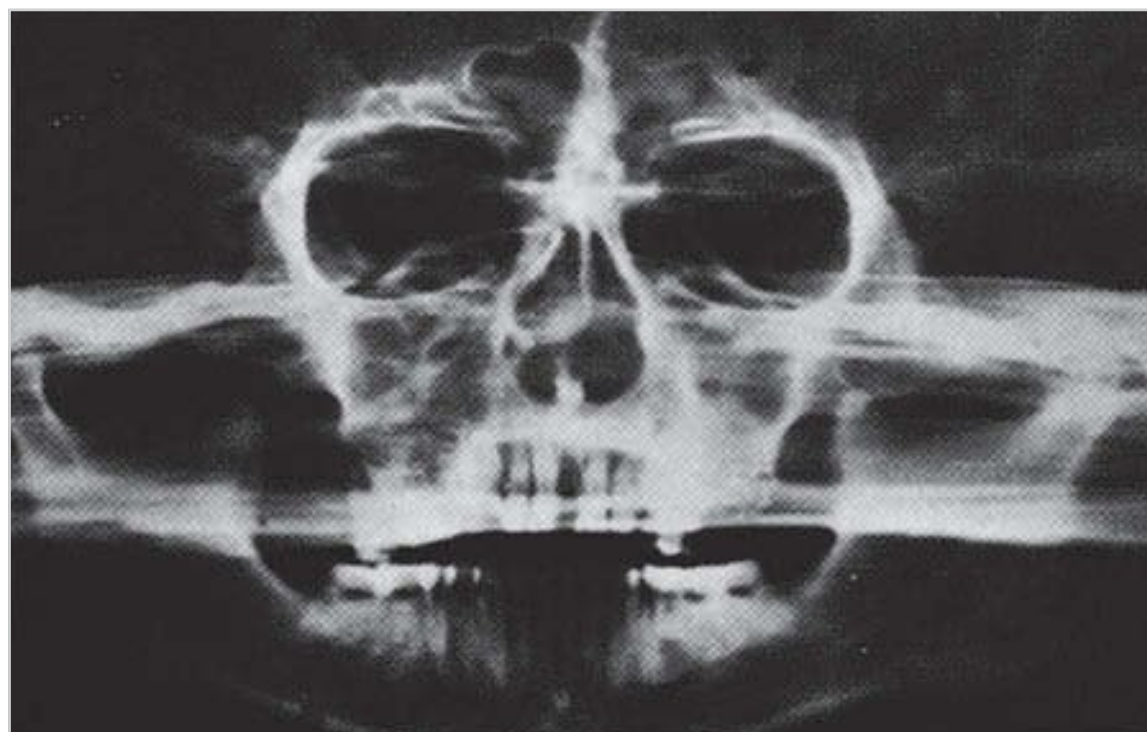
Panoramic radiograph of the image without the tomographic effect.
